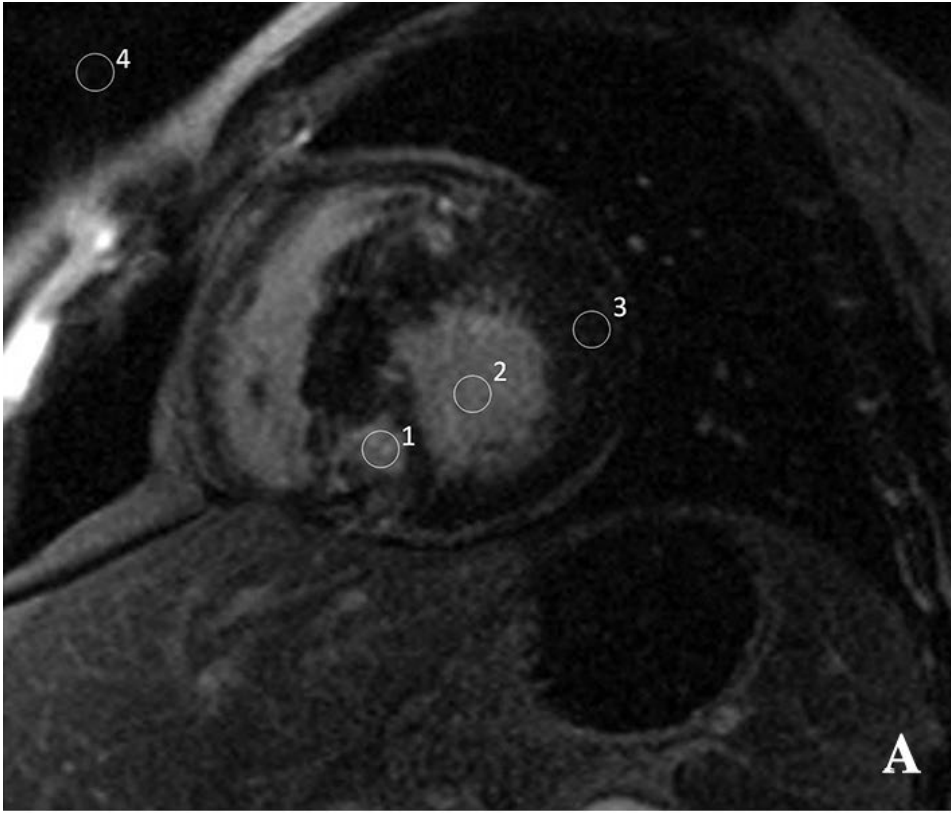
Assessment of signal intensities (SI) on IR-GRE images in a patient with transmural infarction for calculation of CNR. SIs were determined in circular ROIs placed in the scarred myocardium (1), left ventricular lumen (2), and remote myocardium (3) on representative gadopentetate dimeglumine (A) and gadobutrol (B) enhanced MR images.
